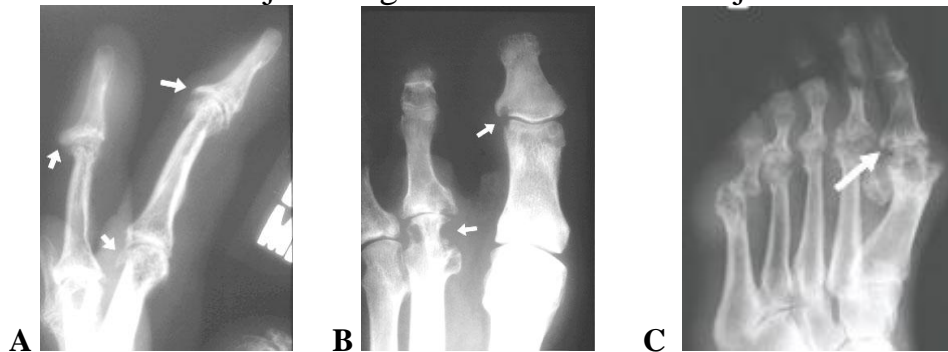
(A) Marked osteophytosis (arrows) and (B) erosions (arrows) at rheumatoid arthritis. (C) Frontal radiograph part of foot, rheumatoid arthritis. Subluxation, concentric loss of joint space, erosions (arrow), and the destruction of the articular surfaces are hallmarks of RA. The soft tissue swelling is anti-cipated
